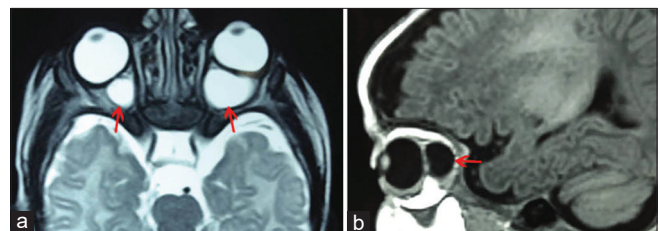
MRI scan of the orbits, axial T2W (a) and sagittal T1 W (b) sequence in parasagittal location, showing bilateral retrobulbar intraconal cystic lesions, isointense to vitreous and probably communicating with the globe. No intracranial communication is seen
